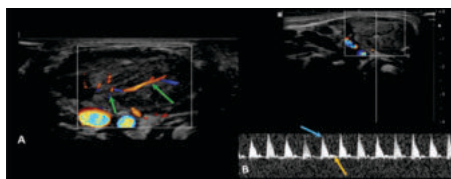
Images A (Colour doppler), Image B (Spectral) shows
